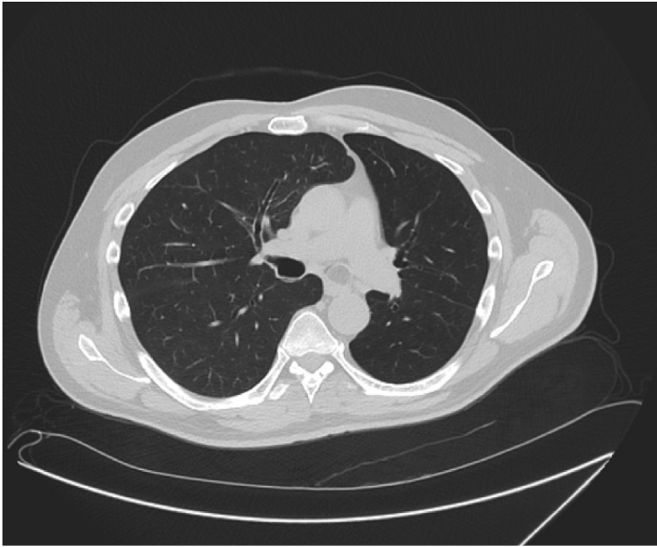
Computed Tomography (CT) of the chest showing the obstructing endobronchial lesion in the left mainstem bronchus.
